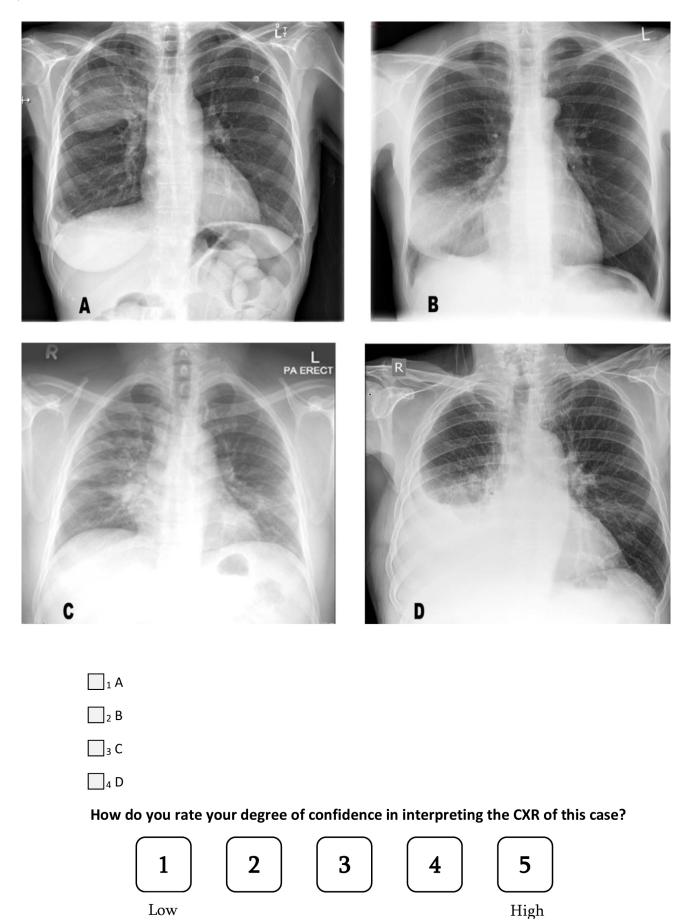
A question from the survey on COVID-19 pneumonia. CXR: chest X-ray.
